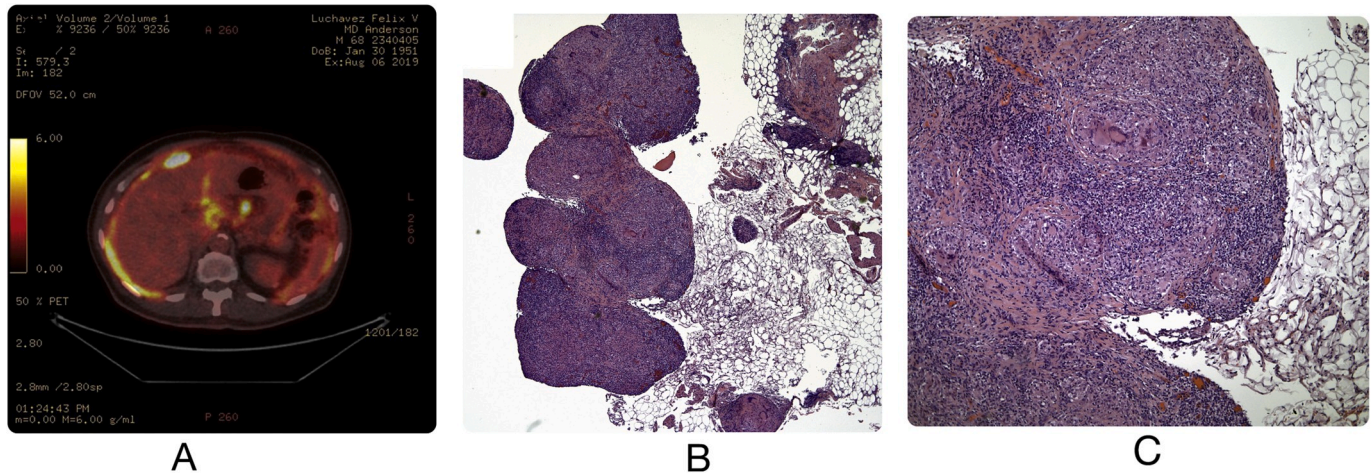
A PET-CT showing increased FDG avidity along nodular right pleural thickening, including mediastinal pleural and new FDG avidity in the peritoneum. B: Pleural biopsy showing florid granulomatous inflammation(low-power field) C: Pleural biopsy showing florid granulomatous inflammation(high-power filed).
